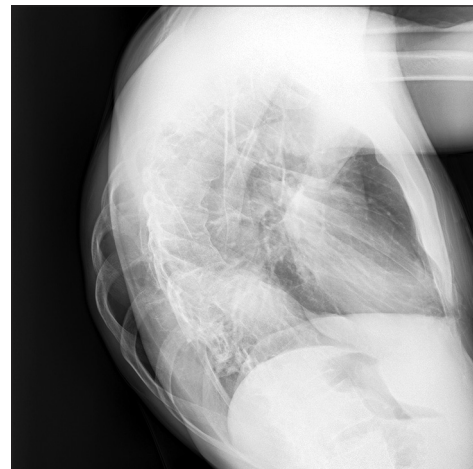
Lateral thoracic radiograph demonstrating severe costal deformity and pronounced thoracic kyphosis
